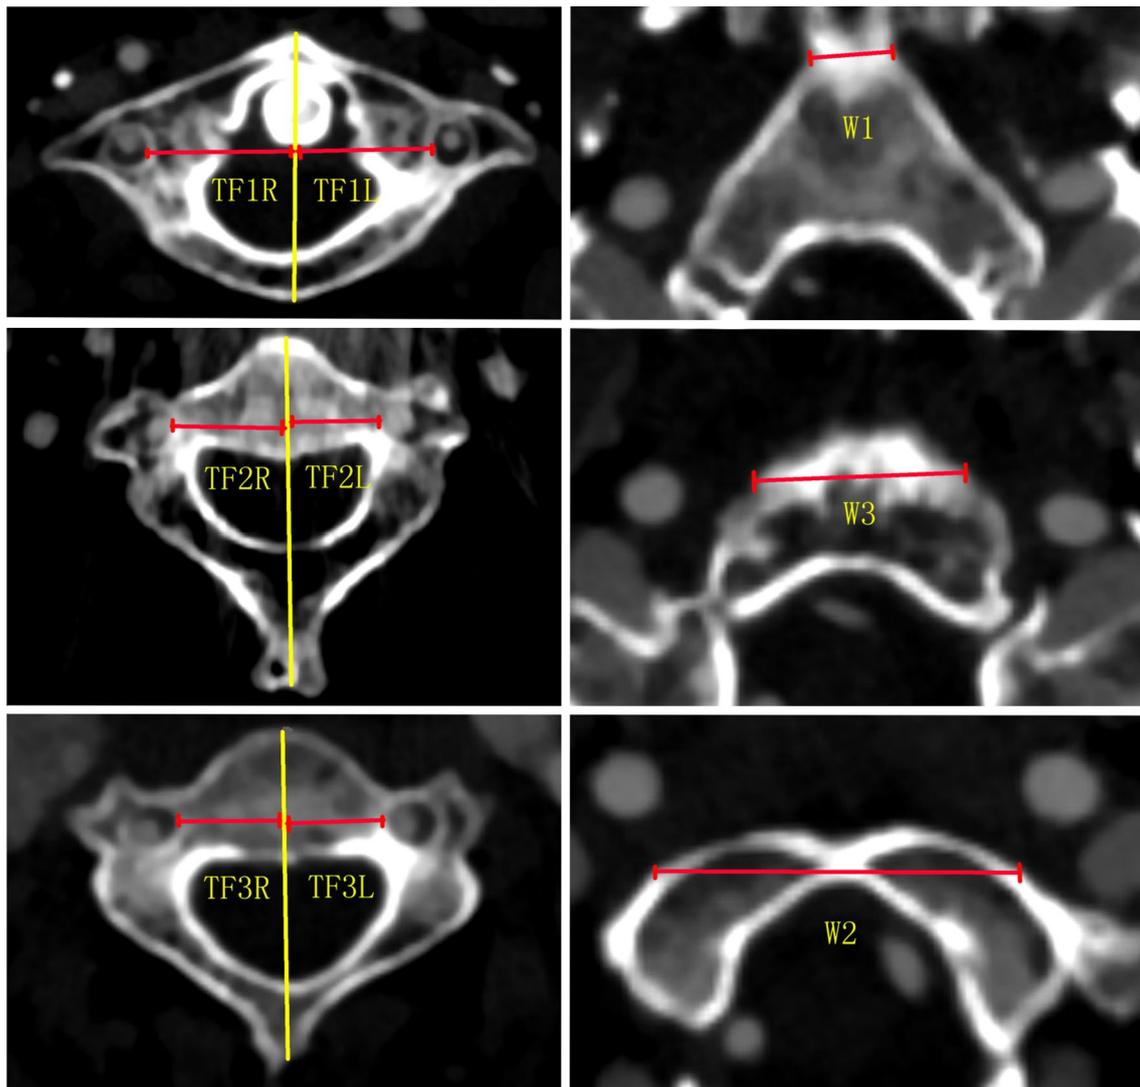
Parameters of clivus and cervical vertebra on CT axial images. W1, W2, and W3 represent the diameter of the extracranial clivus at the level of the top portion, bottom portion, and pharyngeal tubercle, respectively. TF1L, TF1R, TF2L, TF2R, TF3L, and TF3R represent
